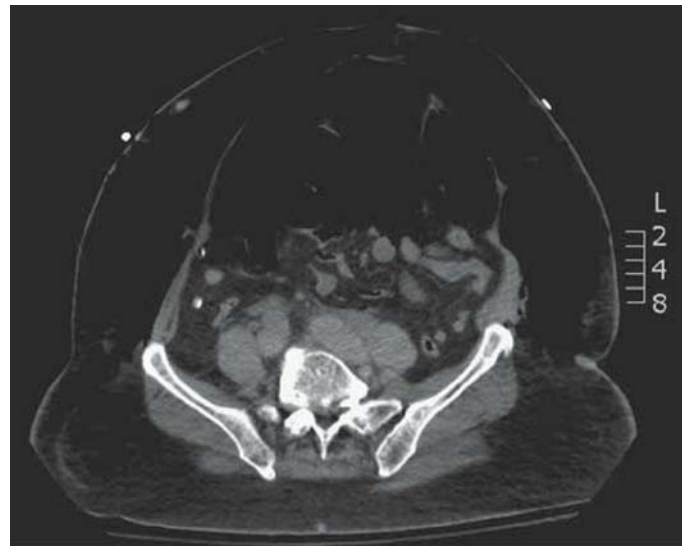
CT in another patient similarly demonstrates that the bowel contents have fallen below the level of the hernia orifice.
